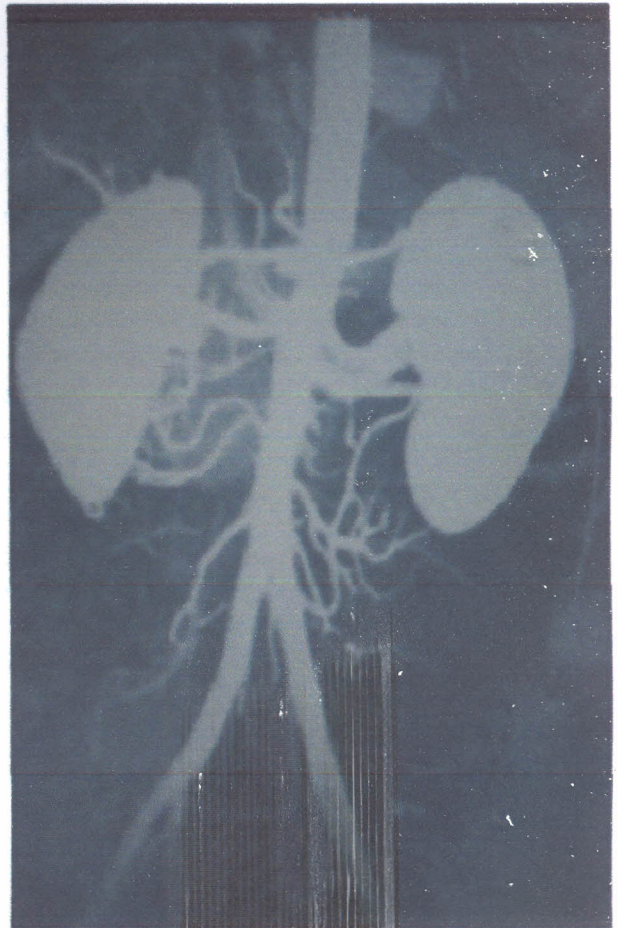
MIP image of normal renal CTA demonstrating normal single renal arteries.
